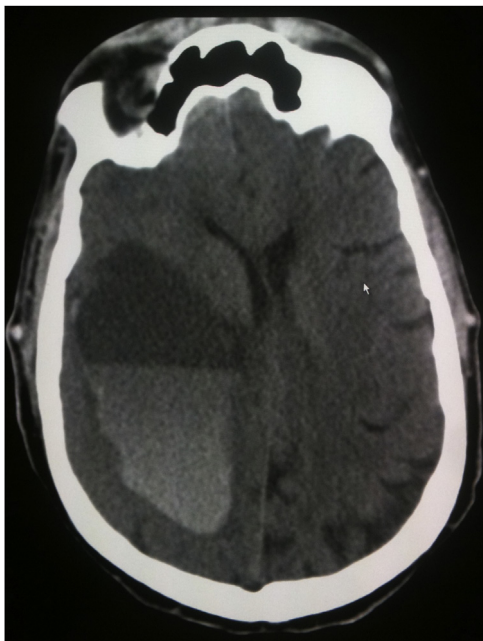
CT head: massive intracranial hemorrhage with edema and midline shift.
